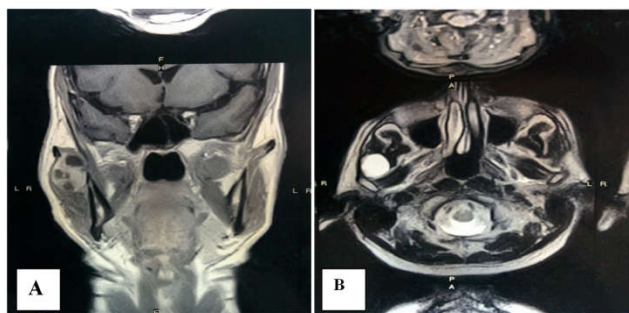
CT scan demonstrating the well circumscribed hyperintense area superficial to the parotid gland.
